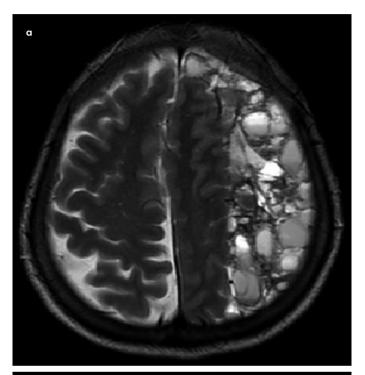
a, b. In the magnetic resonance imaging (MRI) examination, a wide septated subdural hematoma with different components can be seen (a) in the left fronto-parietal area, 6 cm thick in the largest part, causing a 2-cm-thick midline shift, and also containing a large number of septations (b)
